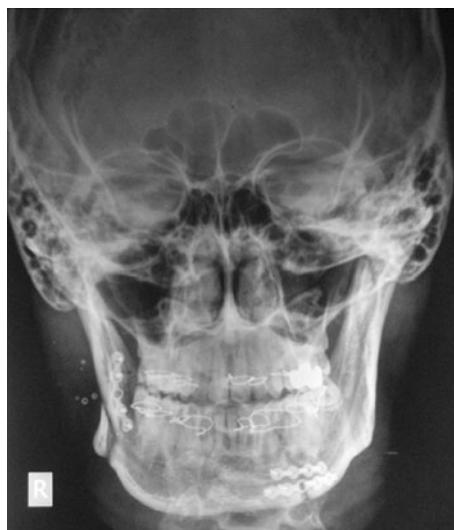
Postoperative PA mandible radiograph
